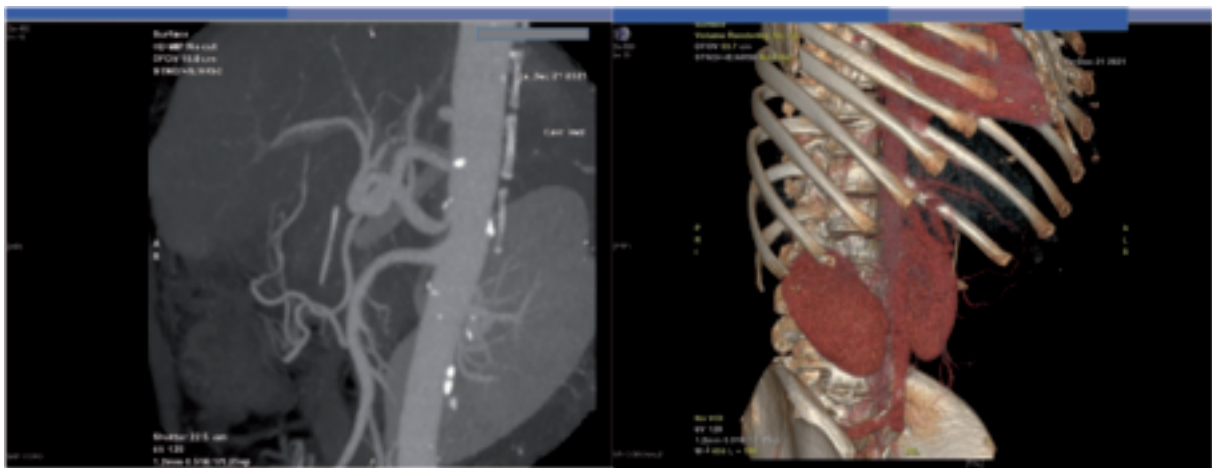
Computed tomography of the abdomen with and without medium contrast. Linear image of 4 cm in length in the posterior wall of the gastric antral region, from which part comes out.
